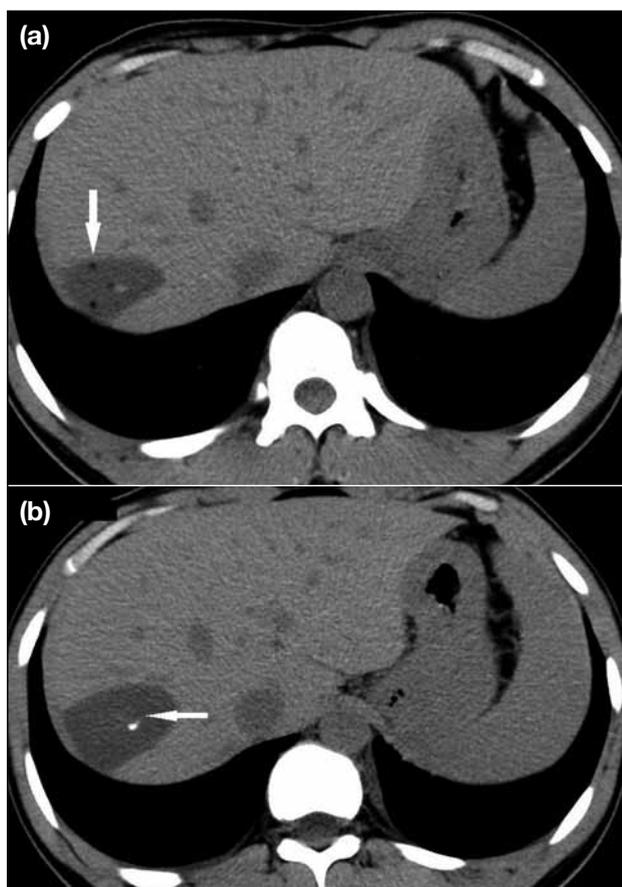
Axial non-contrast computed tomography images of case 2 showing (a) a calcific focus with the hydatid cyst (arrow); and (b) a rounded hypodense cystic lesion in the right lobe of the liver with small hypodense fat attenuation foci within (arrow).
